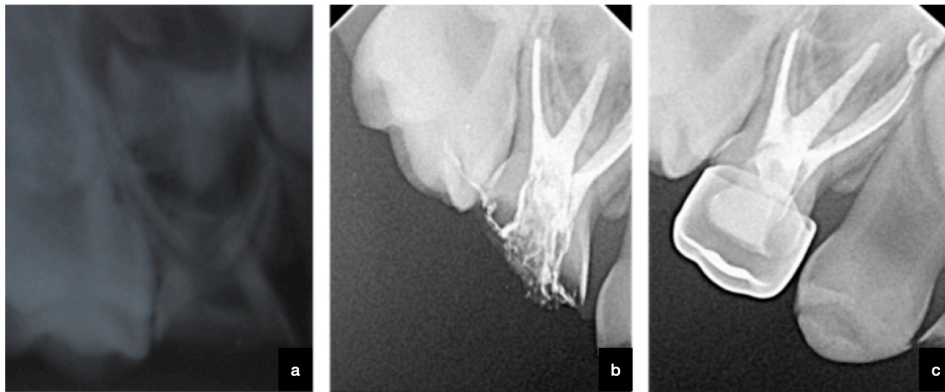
Third RCT performed and primary tooth restoration. (a) Preoperative radiograph of tooth 64 wherein caries is seen involving enamel and dentine, and pulp; (b) Post obturation radiograph after root canal instrumentation; (c) Placement of crowns on 64.
